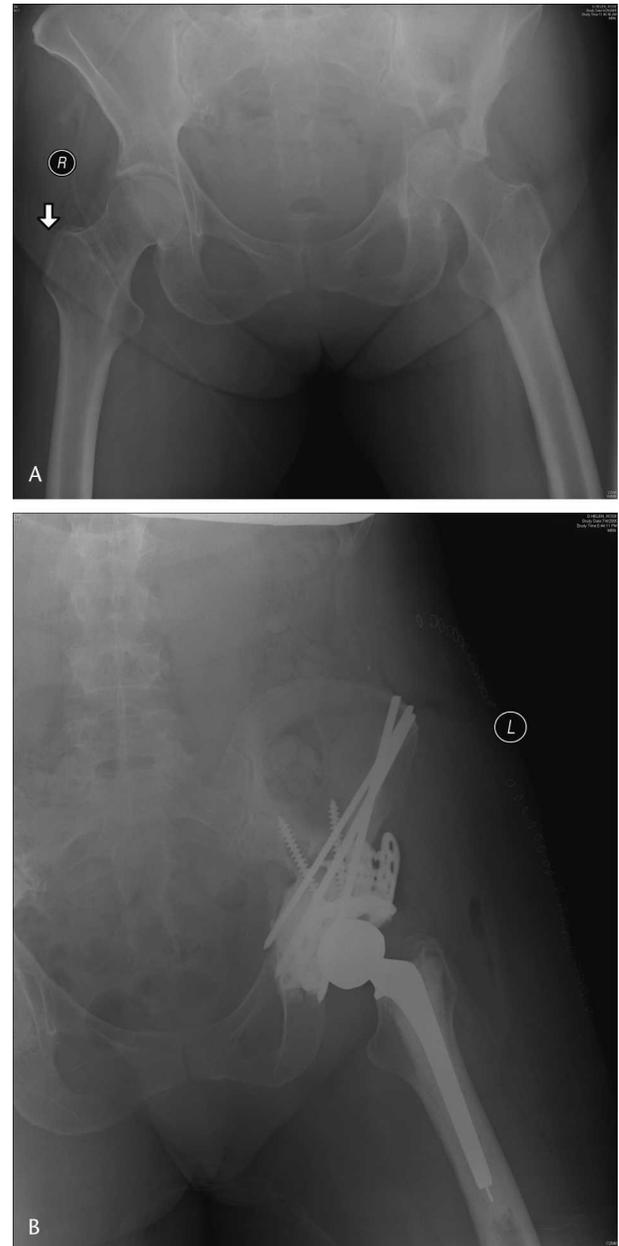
A 50-year-old female with metastatic squamous cell carcinoma of the cervix presented with left hip pain refractory to local irradiation and systemic management. (A) An AP radiograph of the pelvis shows severe acetabular dome and posterior column disease resulting in pelvic discontinuity. (B) The postoperative AP radiograph of the pelvis shows acetabular reconstruction with a roof ring, retrograde long screws into the ilium, and antegrade Steinmann pins from the ilium into the anterior and posterior columns.
